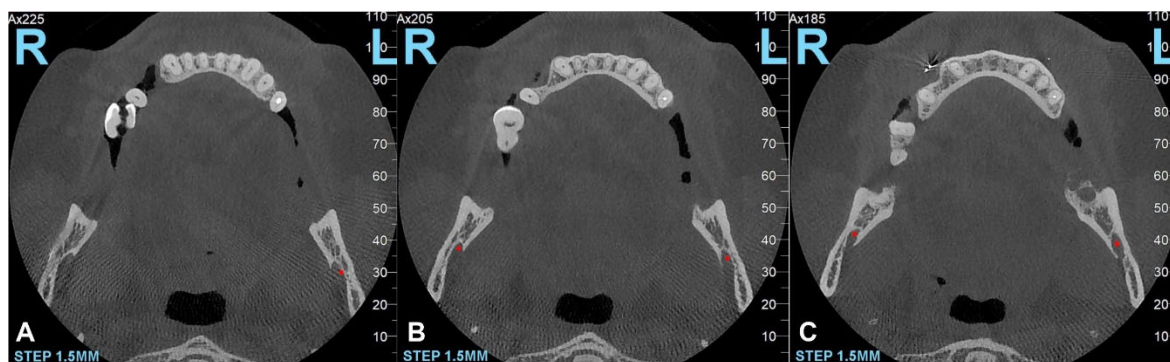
CBCT axial sections parallel to the basilar border showing the main axis of the right mandibular third molar (4.8): (A) Crown of the third molar contacting the distal surface of the adjacent premolar; (B) Horizontal position of the third molar offering a wider, unusual occlusal area for mastication; (C) Alveolar bone separating the roots of 4.8 and the absence of cortical bone at that level. CBCT: Cone-beam computed tomography; R: Right; L: Left.
